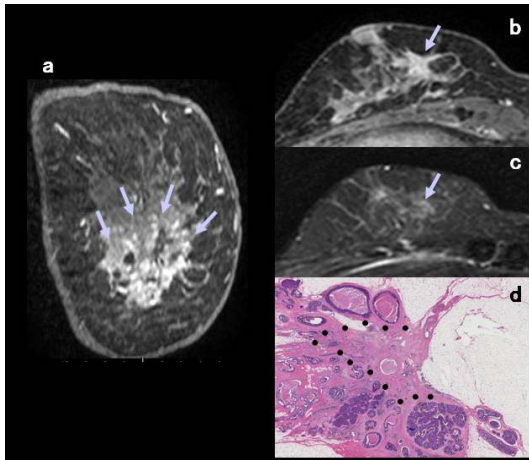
A 62-year-old woman with invasive ductal carcinoma with surrounding DCIS in the right breast. a Coronal multiplanar reconstruction of contrast-enhanced T1-weighted MR image shows non-masslike, segmental enhancement (arrows). b Axial contrast-enhanced image
